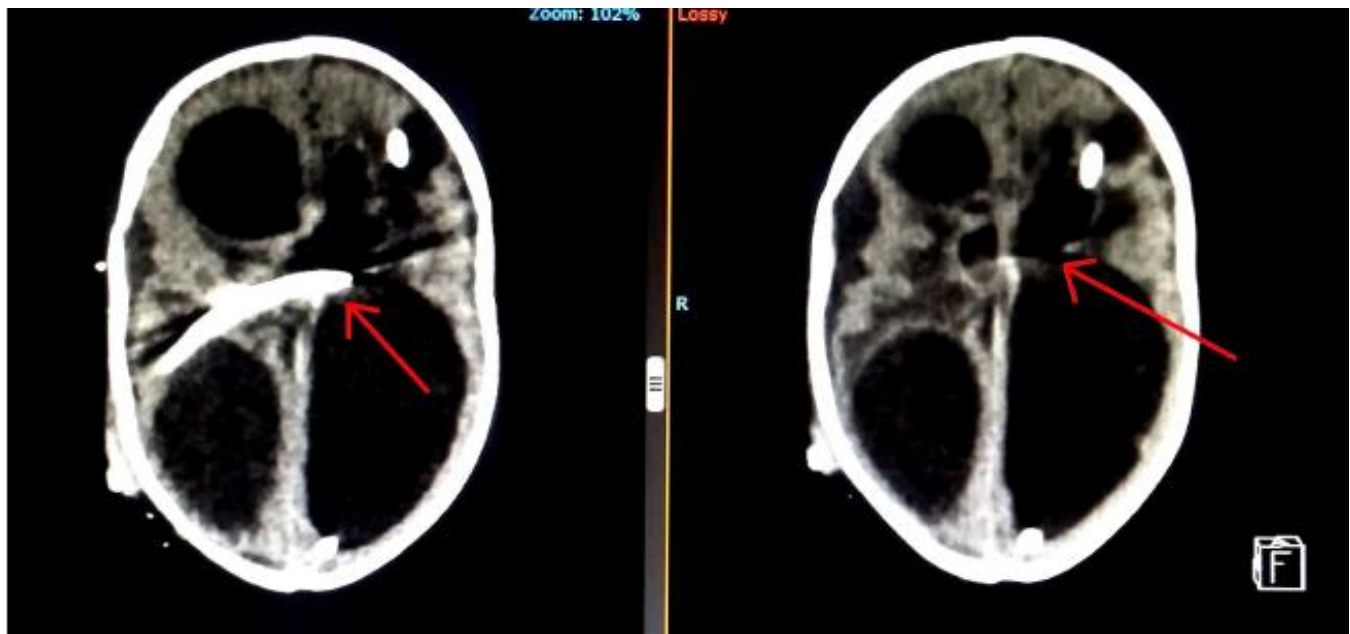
CT Scan Axial Images Showing Intra Ventricular Migration of External Ventricular Drain tube.
